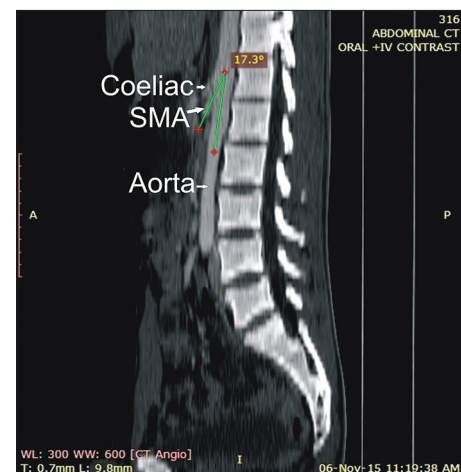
Sagittal reformatted computed tomography image showing the aortomesenteric angle of 17.3°
